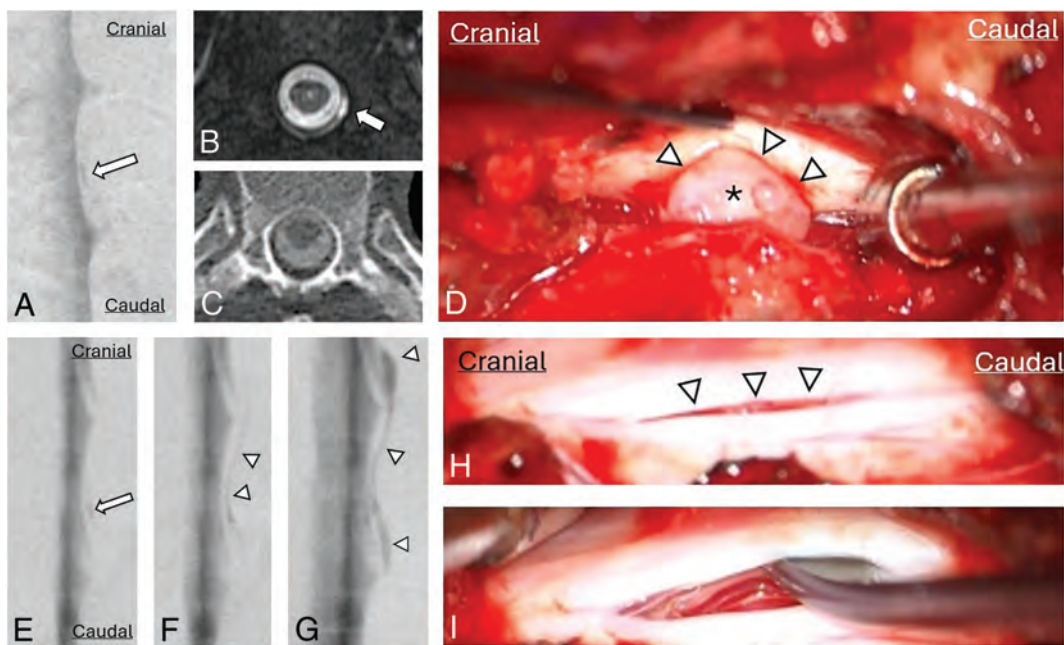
Imaging and intraoperative findings of spontaneous lateral spinal CSF leaks arising at the level of the pedicle. DSM (A) shows a small, defined lateral extradural CSF collection (arrow) at the level of the pedicle, not associated with the nerve root sleeve. Axial T2-weighted MRI (B) shows a corresponding small extradural CSF collection (arrow) that was not visible on post-DSM CT (C). The intrathecal contrast on the post-DSM CT is faint, possibly limiting the sensitivity of leak detection. Intraoperative photograph (D) shows a lateral dural tear (arrowheads) with arachnoid billowing out (asterisk) through the dural defect. DSMs (E–G) show a lateral dural tear (arrow) at the level of the pedicle, not associated with the nerve root sleeve, resulting in an extensive CSF leak, with CSF spreading in both cranial and caudal directions (arrowheads). Intraoperative photographs (H and I) show a linear dural tear (arrowheads) without arachnoid protruding through the dural tear. The underlying spinal cord is visible after spreading the dural tear (H).
